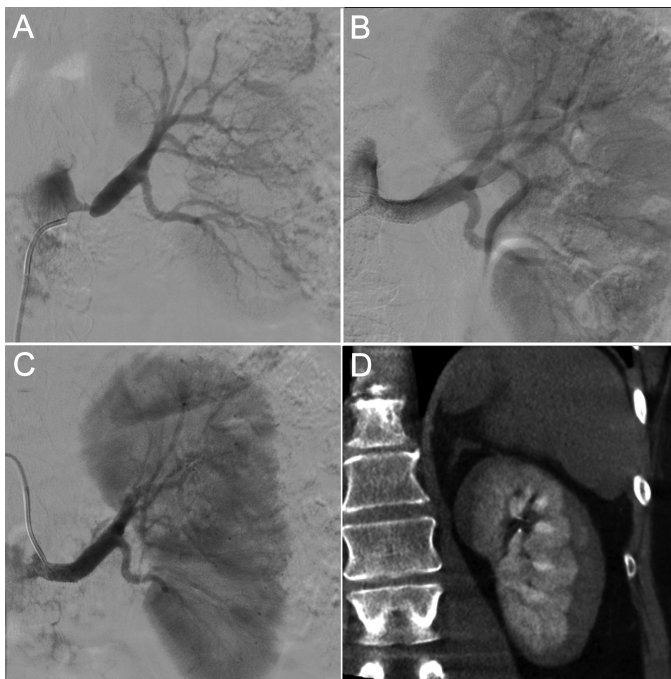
(A) Digital subtraction angiographic image of left renal artery before the procedure showed severe ostial narrowing that required stenting. The branches of the left renal artery and contrast enhancement of the parenchyma were normal. (B) Digital subtraction angiographic image of the left renal artery after transluminal angioplasty revealed normal renal artery caliber. (C) Digital subtraction angiographic image of the left renal artery was taken 40 minutes after the procedure upon the patient's complaint of flank pain. The angiography showed multiple microaneurysms especially at the distal renal artery branches and the presence of a slightly compressed renal parenchyma along the long axis on the coronal view. (D) Cone-beam tomography, carried out to reveal the cause of parenchymal compression, showed the presence of subcapsular hematoma with compressed and displaced left renal parenchyma.
